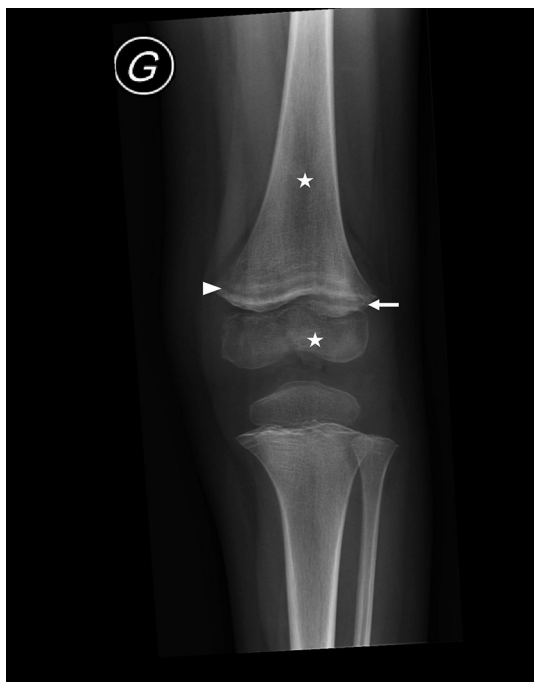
Left knee radiograph for case 1, a 3-year-old boy, demonstrating multiple clear metaphyseal bands in the distal femur (white arrowhead), also defined as “Trummerfeld zone,” and marked white line corresponding to thickened zone of calcification, also named “white line of Frankel.” Irregular and enlarged metaphyseal margin (white arrow), as well as diffuse osteopenia (stars) are also noted.
